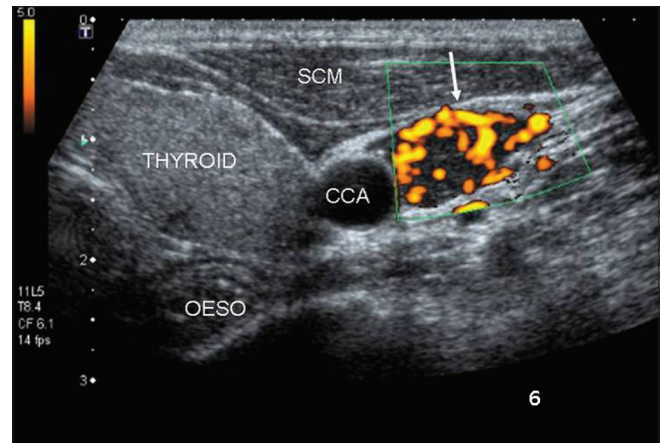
Transverse ultrasound Doppler image of the neck at the level of lower pole of thyroid, showing a well-defined hypoechoic lesion posterior lateral to the carotid artery (relationships as shown). Power Doppler shows marked vascularity within the lesion
